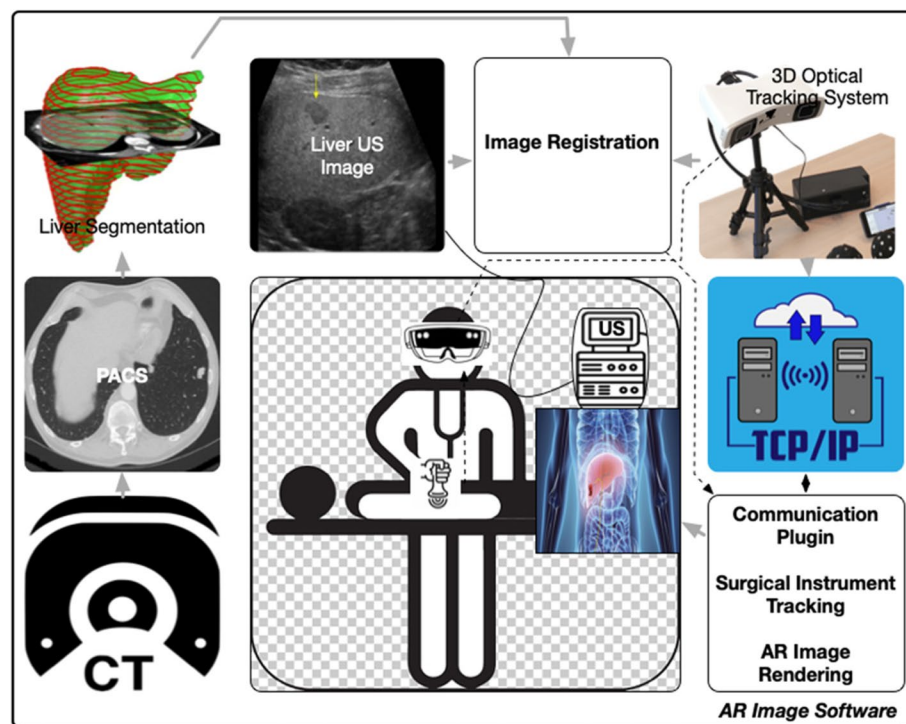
Projection of CT-US image fusion in AR to highlight sparse lesions
